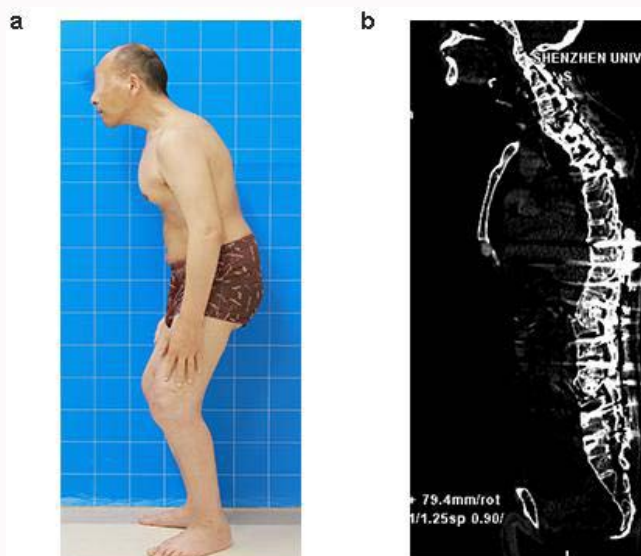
a) Shown the lateral view of the patient after four stages operations. b) Shown the sagittal CT examination after all stages of operations, which can see that ankylosing spondylitis was corrected basically.
